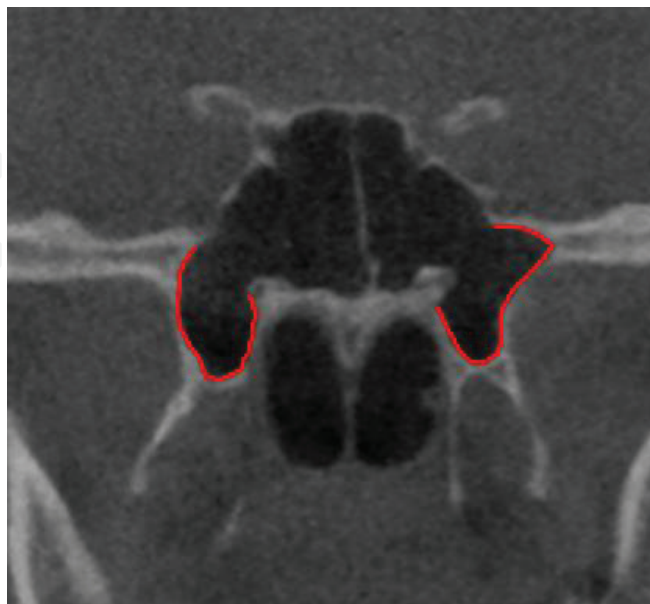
Coronal CBCT images show the bilateral remarkable PP pneumatization.
